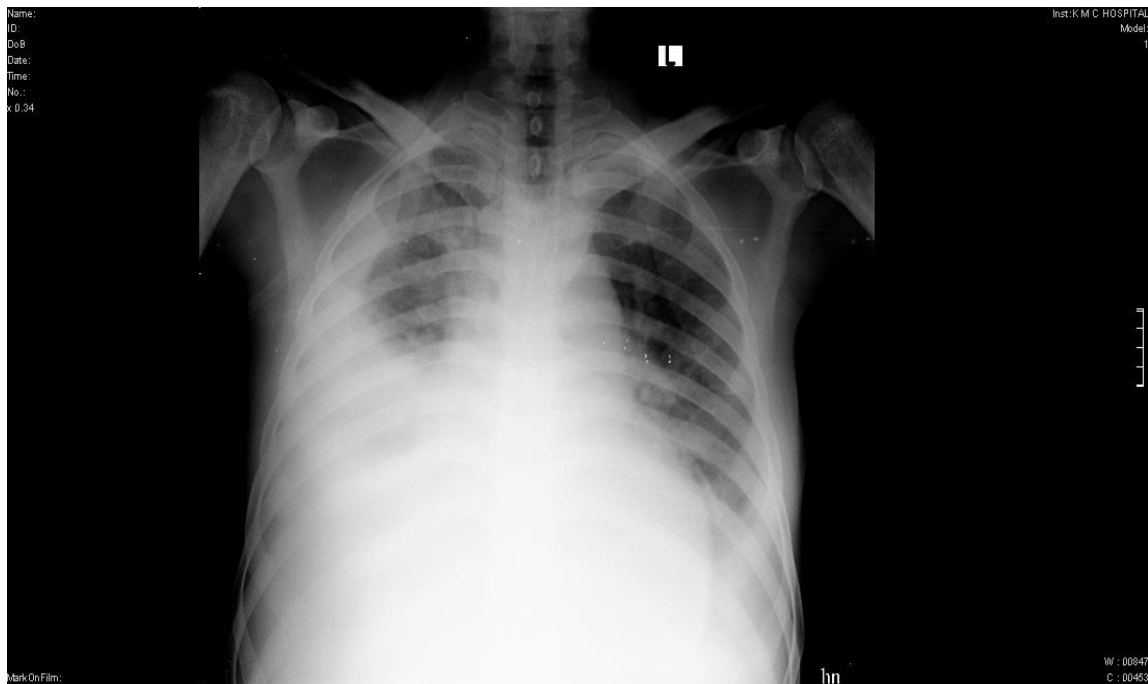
Chest X-ray showing a right side pleural effusion (left side of the image).
